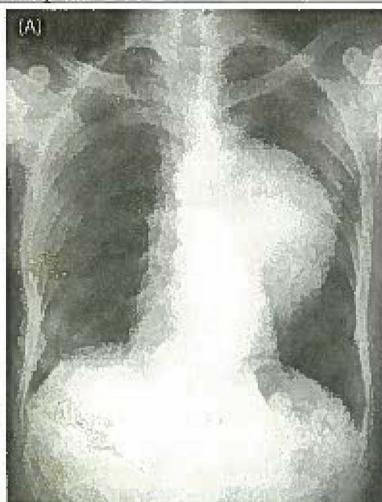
(A) X-ray chest showing aneurysm of aorta, (B) Aortic Aneurysm
